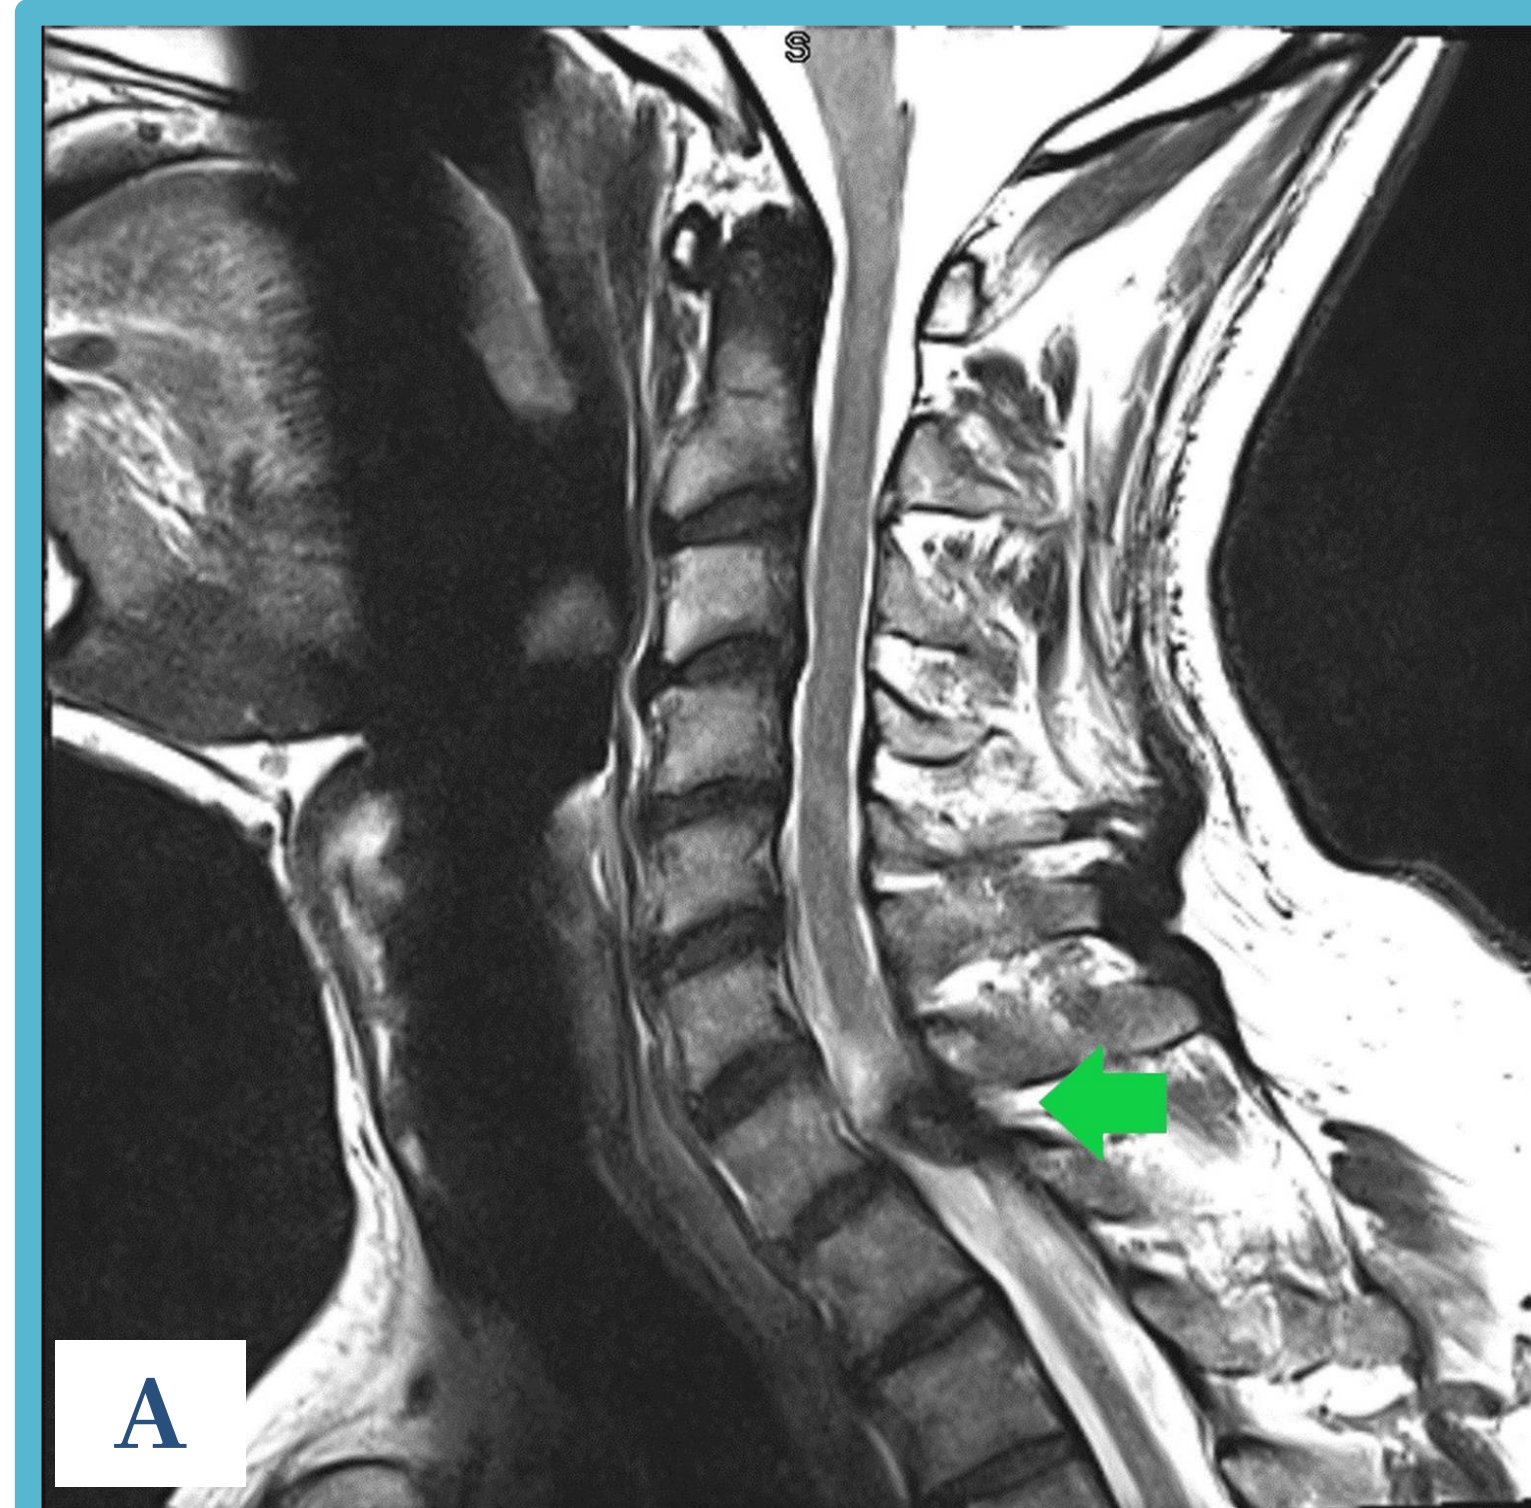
T2-weighted (A & B) and contrast enhanced (C & D) sagittal and axial images of cervical spine, spinal cord and surrounding structures, with green arrows identifying synovial cyst
